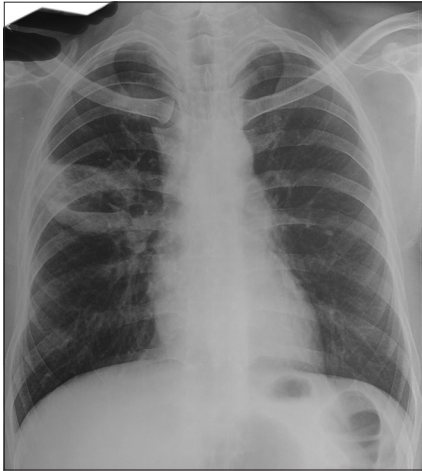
X-ray chest showing right mid zone cavitory lesion
